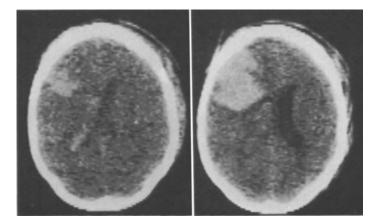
Left: CT: Left frontal hematoma with CSF-blood mixture in the left lateral ventricle in a 25-year-old girl who was somnolent on admission. Right: CT 24 hours later of the same patient: Enlargement of the hematoma. The patient became comatose. Removal of the hematoma resulted in rapid improvement
